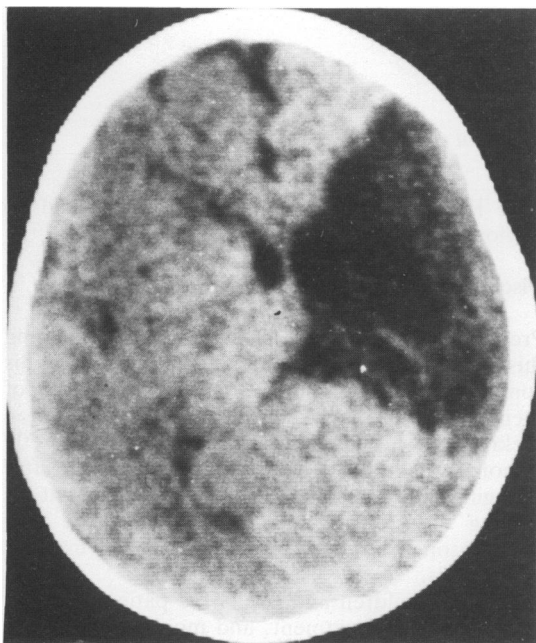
Figure Computed tomogram at 7 months old showing large cystic structure (presumed infarct) in area of right middle cerebral artery.
